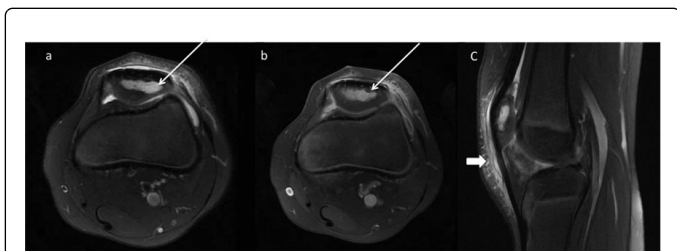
A 6-year-old girl with *K. kingae* osteomyelitis of the left patella. The bone lesion (thin arrow) and pre-patellar soft tissue swelling (thick arrow) are shown on a fat-saturated T2-weighted axial image (a) post-gadolinium fat-saturated T1-weighted axial image (b) and fat-saturated T2-weighted sagittal image (c).
